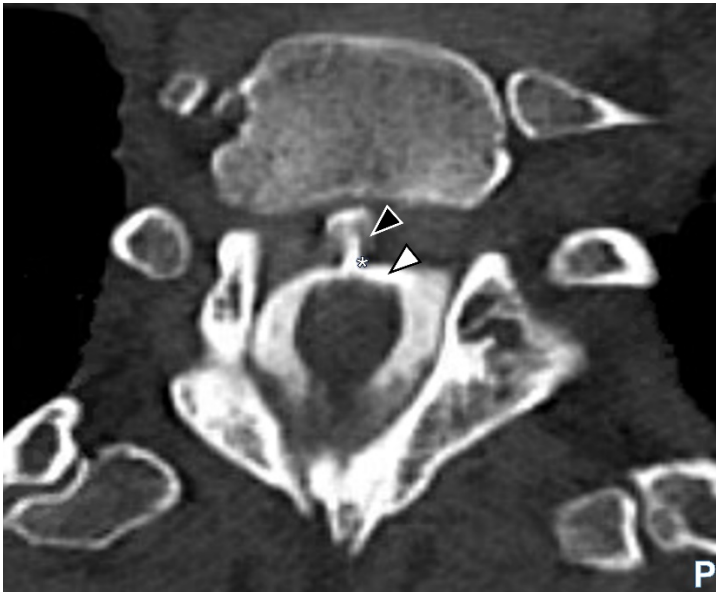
Axial CT myelogram image showing contrast (white arrowhead) in the cerebrospinal fluid (CSF) and clearly visible extravasation of contrast (black arrowhead) at the site of dural defect (asterisk) in the thoracic region. Legend: CT computerised tomography; P posterior.
